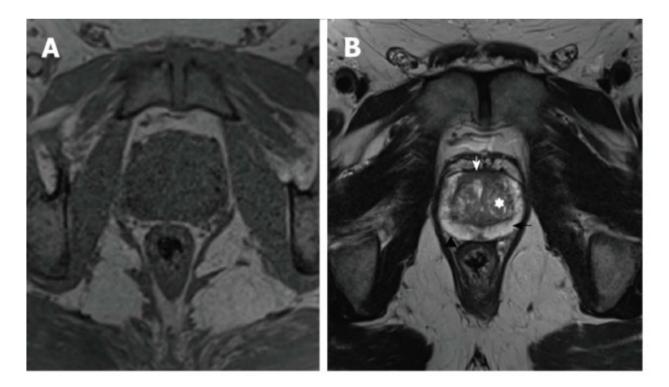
Prostate anatomy on T1- and T2-weighted Magnetic resonance images. A: Axial T1-weighted MRI of the human prostate. The organ appears as an isointense homogeneous gland. Differentiating the anatomical details in the prostate is challenging. B: T2-weighted axial MRI prostate anatomy. White arrows indicate the anterior fibromuscular stroma. Black arrows point to the peripheral zone (PZ) recognizable as a hyperintense U-shaped tissue. The white asterisk is the transitional zone (TZ) which appears hyperintense and has a multi-nodular pattern. (1)
